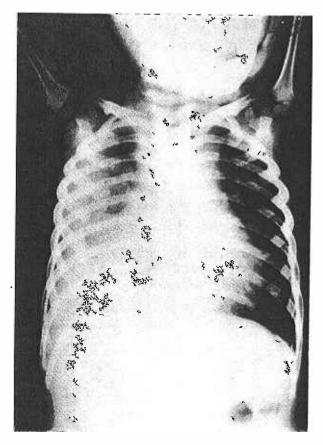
Radiograph of the chest to show very little clearing after $1\frac{1}{2}$ years of antituberculous therapy.
